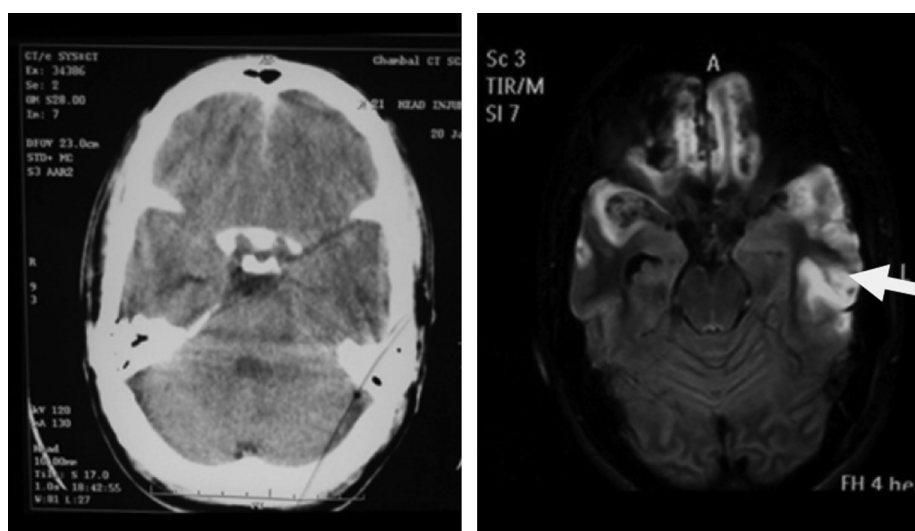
Comparison of CT and MRI (FLAIR) images showing development of fresh contusion and SAH, which was not evident in CT scan.
